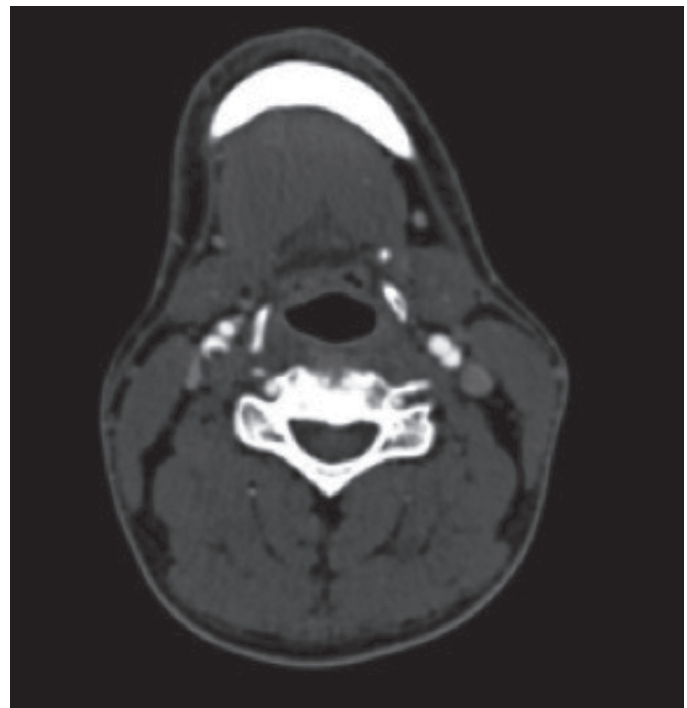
Computed tomography showing floating thrombus in the right internal carotid artery
